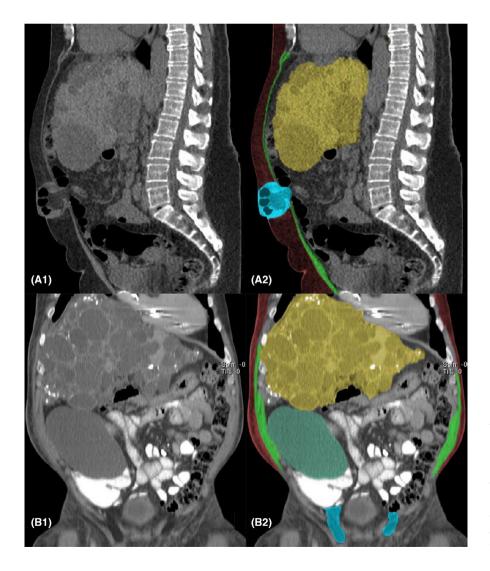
CT imaging of two patients with abdominal wall hernias. Patient A umbilical hernia and patient B double inguinal hernia. The subcutaneous tissue is coloured red, the abdominal muscle tissue light green, the AWH in cyan, the polycystic liver is coloured yellow and a single kidney cyst is coloured dark green. AWH, abdominal wall hernia; CT, computed tomography
